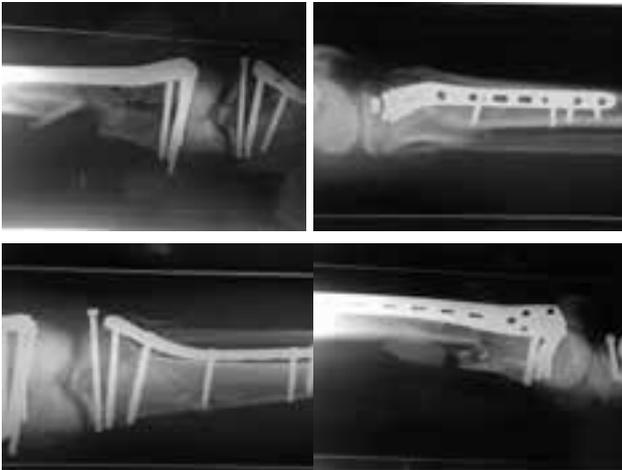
Immediate postoperative radiograph of both tibia and femur managed by MIPPO
